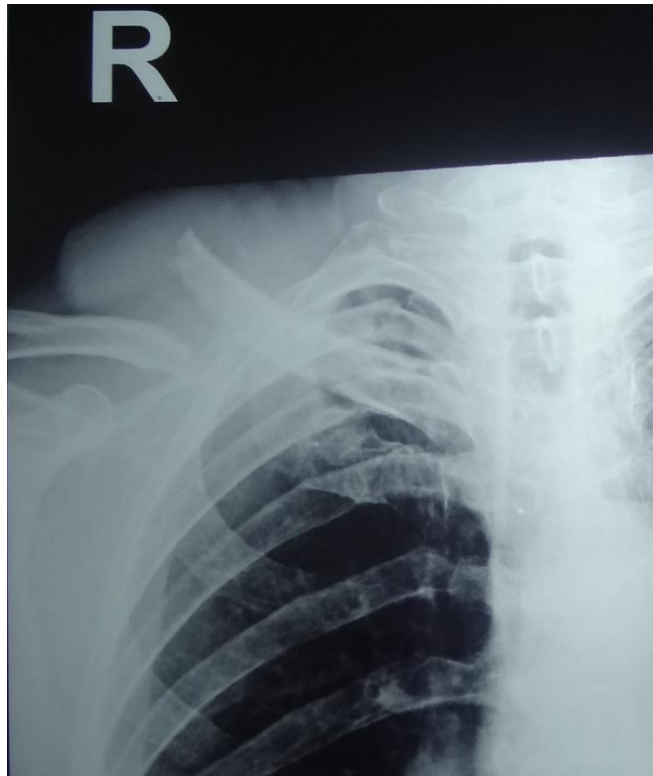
Radiograph showing fracture of right clavicle.
